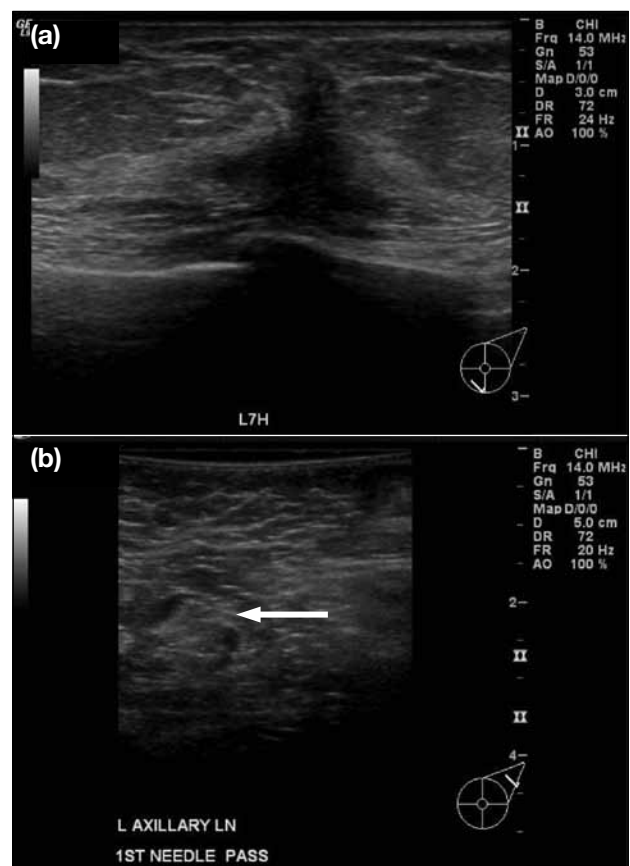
Transverse ultrasound-guided image of a benign axillary lymph node in a patient with carcinoma of the left breast. (a) Hypoechoic 'taller than wide' spiculated mass in left breast, biopsy confirmed invasive ductal carcinoma. (b) Image of axillary lymph node shows oval shape, thin cortex and central fatty hilum, with an arrow showing the tip of needle for aspiration.
